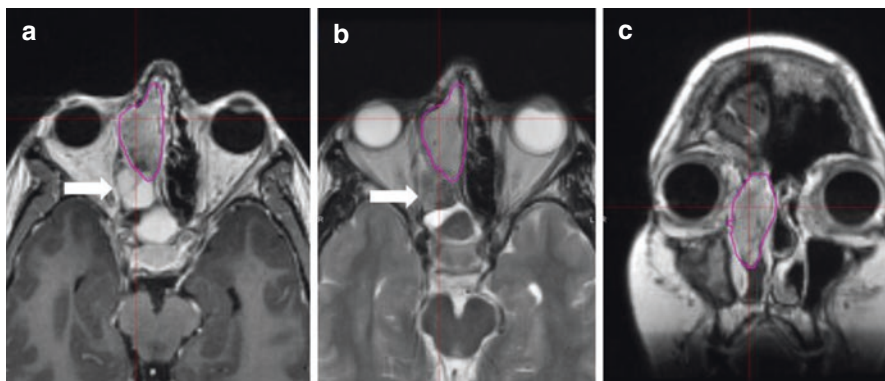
Diagnostic preoperative MRI of a T3 N0 M0 right naso-ethmoidal sinonasal intestinal-type adenocarcinoma. (a) Contrast-enhanced axial T1-weighted image. (b) Axial T2-weighted image. (c) Contrast-enhanced coronal T1-weighted image. Note that both T1- and T2-weighted images are useful in distinguishing tumor from benign mucosal secretions (*arrows*), which is often characterized by high-intensity T2 signal. However, in this case, these secretions contain proteinaceous material and also appear low intensity on T2. The pre-opGTV is outlined in the *magenta contour*
